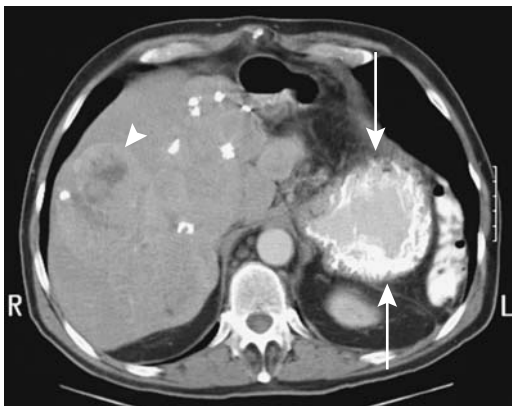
Metastatic islet cell carcinoma. Computed tomography reveals a calcified tumor in the pancreatic tail (arrows) and a liver metastasis (arrowhead). The patient has had a previous left hepatectomy. (Courtesy of Patrick Fultz, M.D., University of Rochester.)
